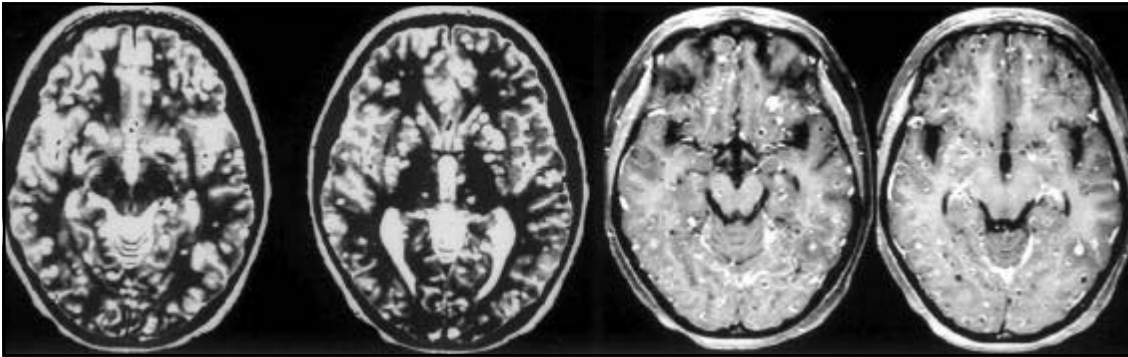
MRI Axial T2WI and T1WI postcontrast (Gd-DTPA):Miliary form.
